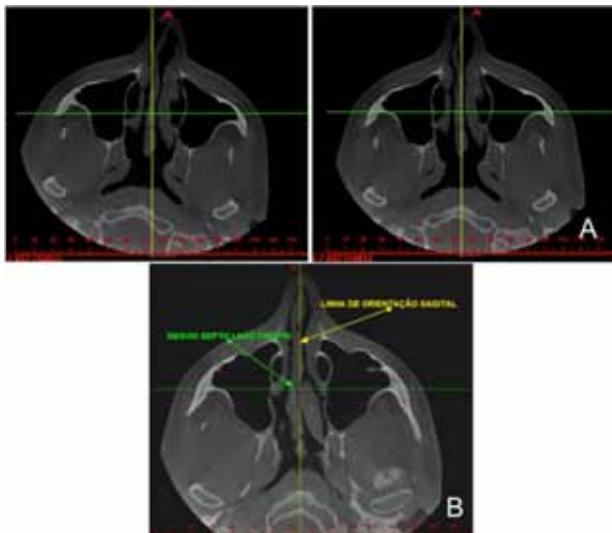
CBCT axial slices showing: (a) previous alignment of the image to the sagittal plane (in yellow); (b) nasal septum deviation to the right side.
